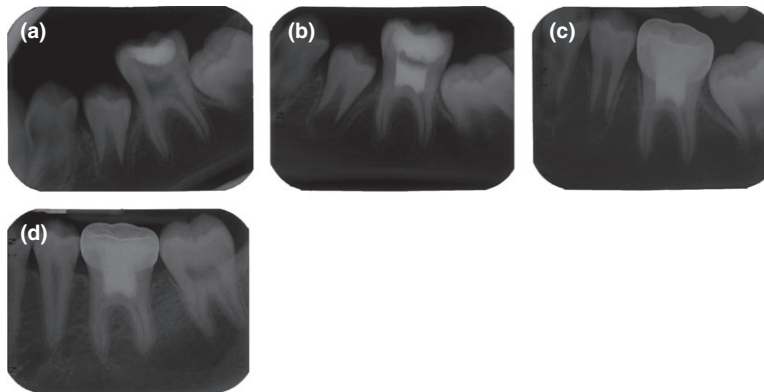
Radiographic evaluation of case 10 (a) preoperative radiograph demonstrating an immature root development of tooth 36, (b) immediately after MTA pulpotomy, (c) 7-month postoperative radiograph demonstrating a dentinal bridge formation and (d) 5-year postoperative radiograph.
